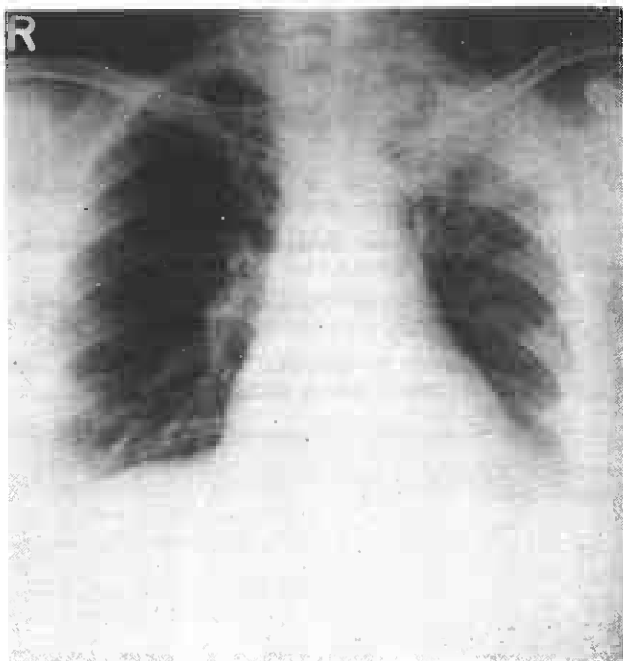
Chest x-ray showing tuberculous infiltrations in the left upper zone
